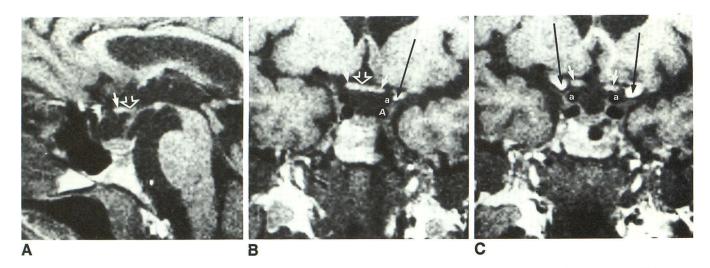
MR appearance of enlarged primary empty sella with no suprasellar visual system or third ventricle herniation. Comparison with CT showed distinctive imaging advantage of MR over CT. A 19-year follow-up comparison with pneumoencephalogram with tomography documented no interval change.
